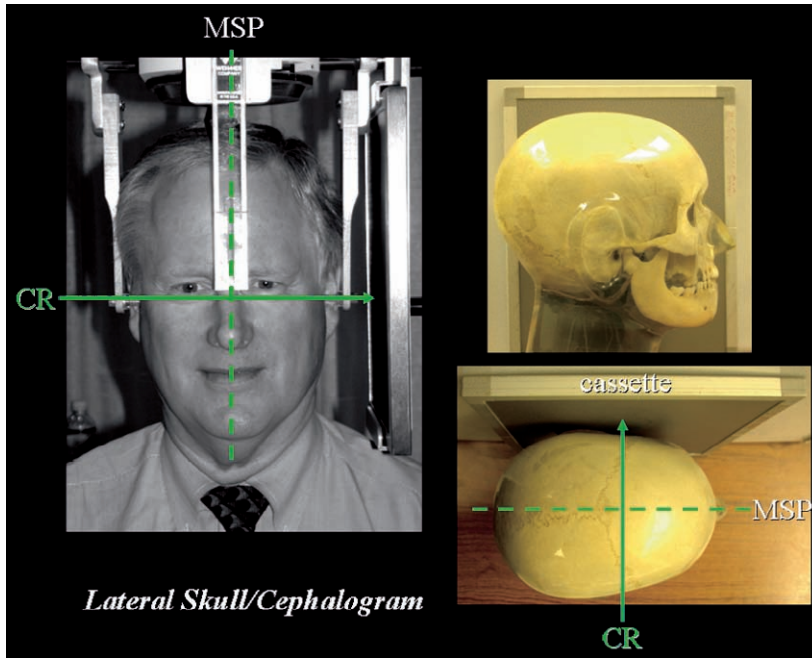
Lateral skull projection. The use of a cephalostat makes the radiographic image a cephalogram suitable for orthodontic analysis. CR Central ray, MSP midsagittal plane. The left side of the face is toward the cassette
